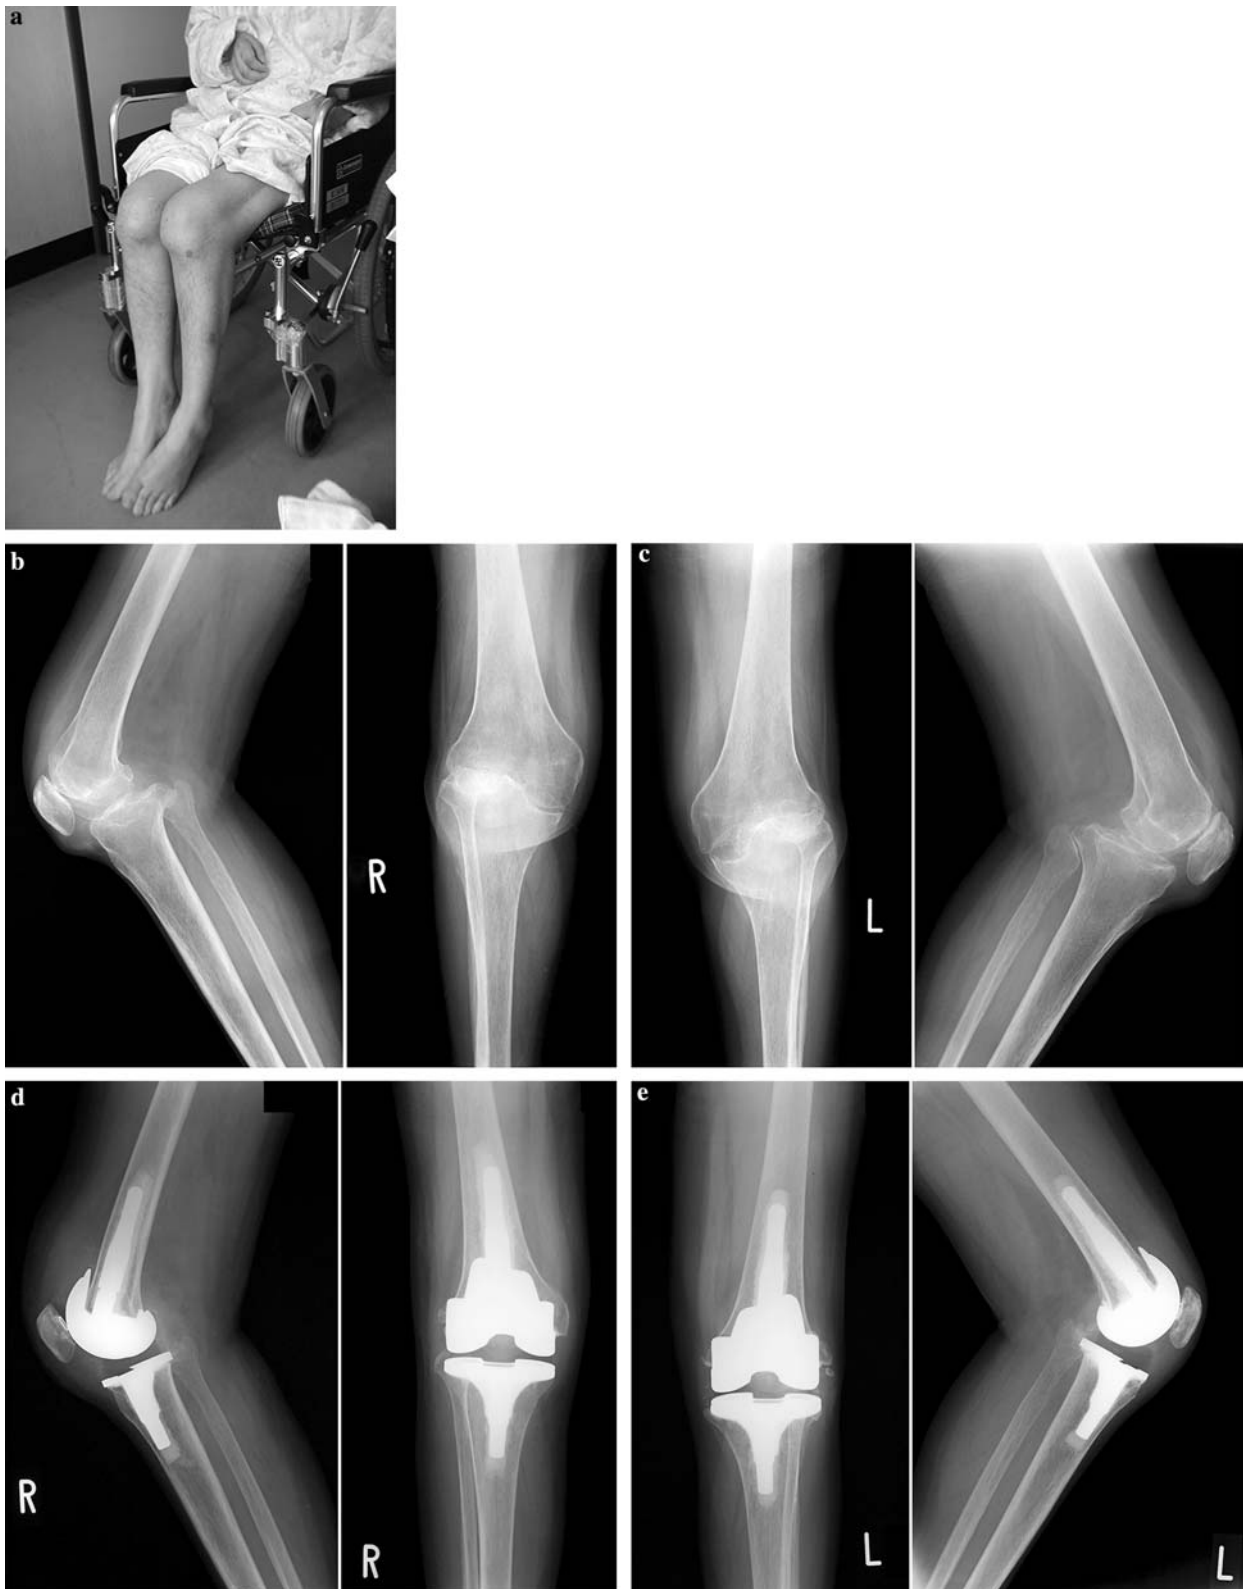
Patient 3. a Preoperative condition of patient. The patient had been unable to leave the wheelchair by herself. b Plain anteroposterior, lateral radiograph of the right knee. c Plain anteroposterior, lateral radiograph of the left knee. d Plain anteroposterior, lateral
